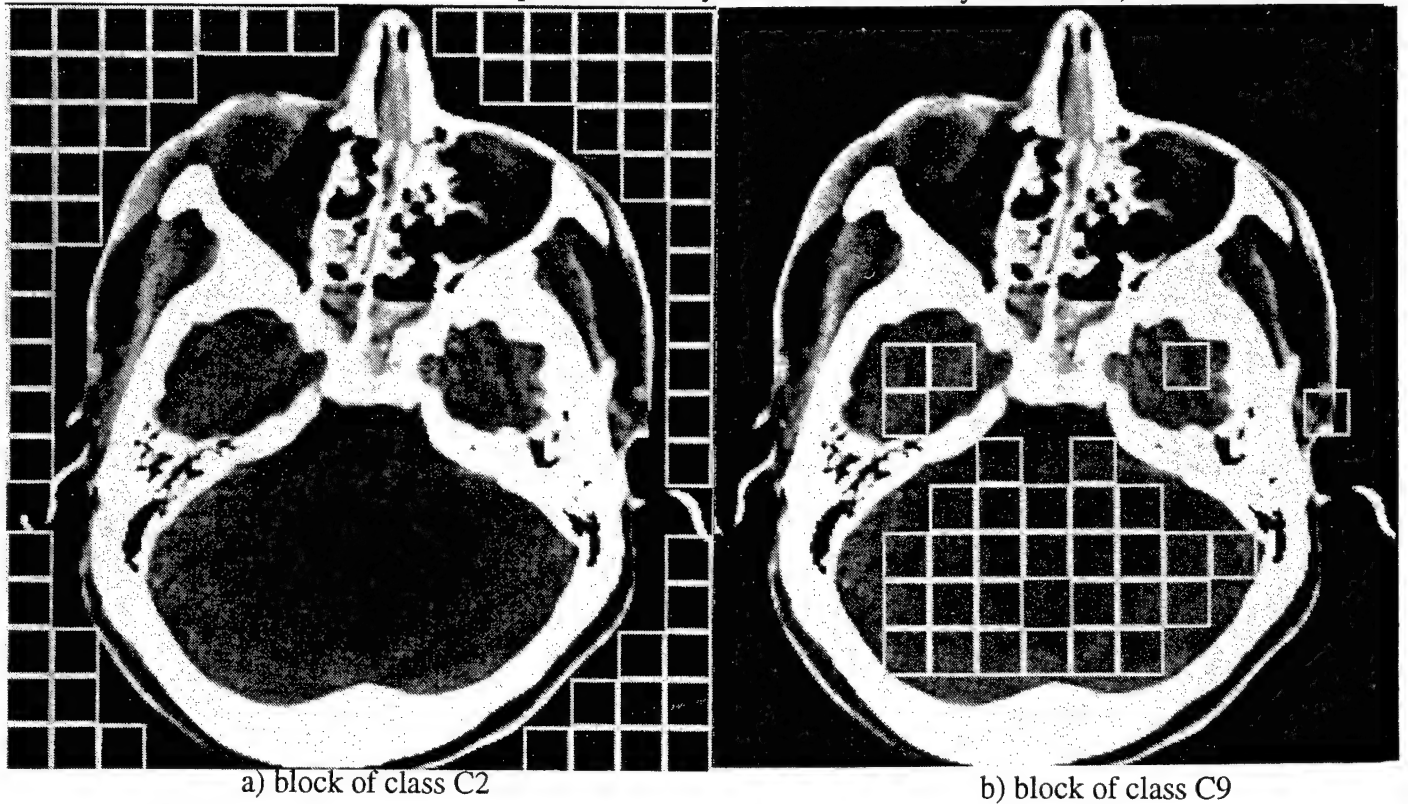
Head computed X-rays tomography
